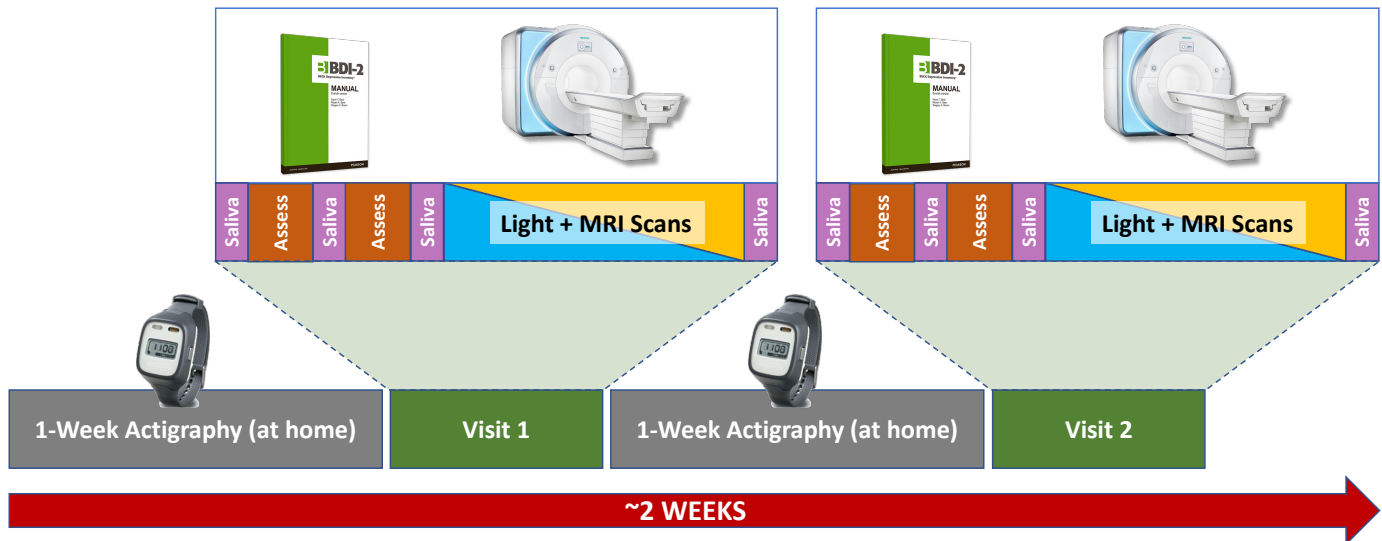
Study Design: Participants were sent an actigraphic sleep watch to wear for one week prior to coming to the lab. The actigraph measured sleep during the week. Then, the participant attended Visit 1, which involved an initial saliva sample, a 1-hour series of behavioral assessments and self-report inventories, two additional saliva samples, and a 1-hour neuroimaging scan. During the scan participants were either exposed to blue light or amber light during various functional magnetic resonance imaging scans. The same light color was used throughout the entire Visit 1 session for all scans. Upon leaving the scanner, participants provided a fourth saliva sample for melatonin analysis.
